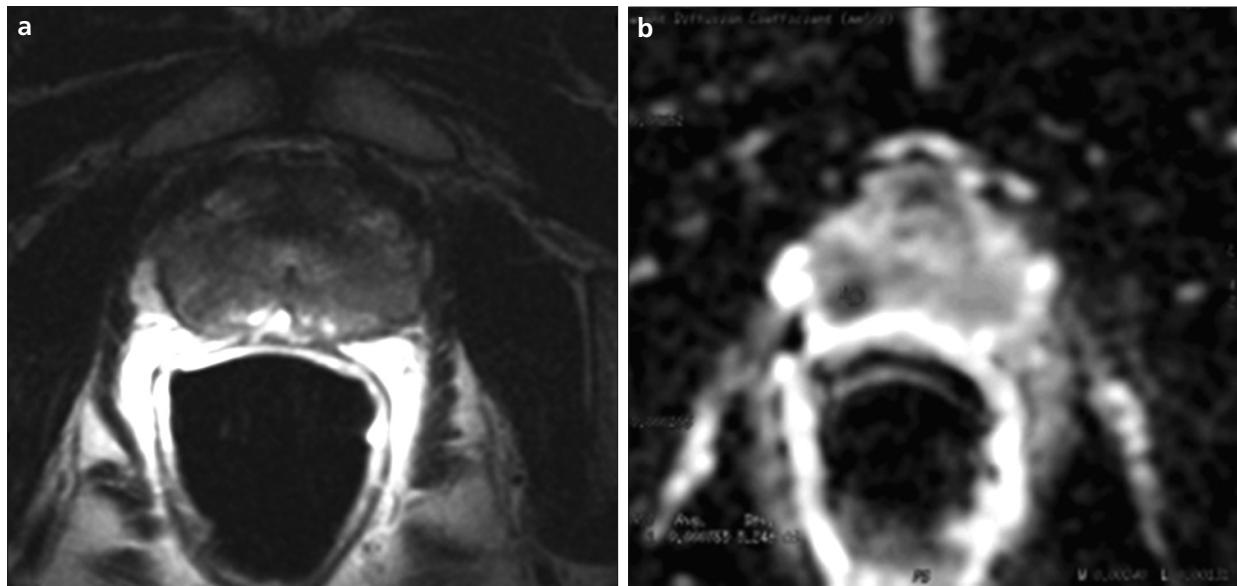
a, b. A 71-year-old man with prostate cancer in the right peripheral zone. Prostate-specific antigen was 4.0 ng/mL, and Gleason score was 7. Endorectal T2-weighted transverse MR image (a) showing a generalized low signal intensity in the peripheral zone bilaterally and no focal lesion. However, the apparent diffusion coefficient (ADC) map (b) shows a clear focal lesion with low signal intensity in the right peripheral zone, within the sextant that was biopsy-positive for tumor. A circular region of interest of 14 mm² superimposed on the lesion reveals a minimum ADC value of 0.765x10⁻³ mm²/s.
